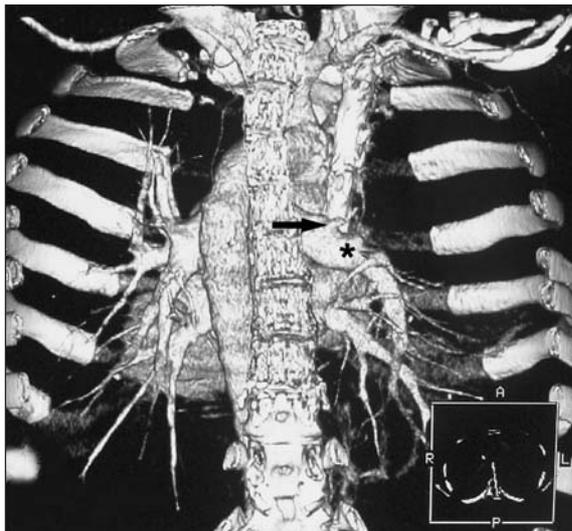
Coronal volume-rendered three-dimensional CT angiography, posterior view, shows occluded right upper lobe artery (arrow). Also note the middle lobe arterial stump (asterisk).
